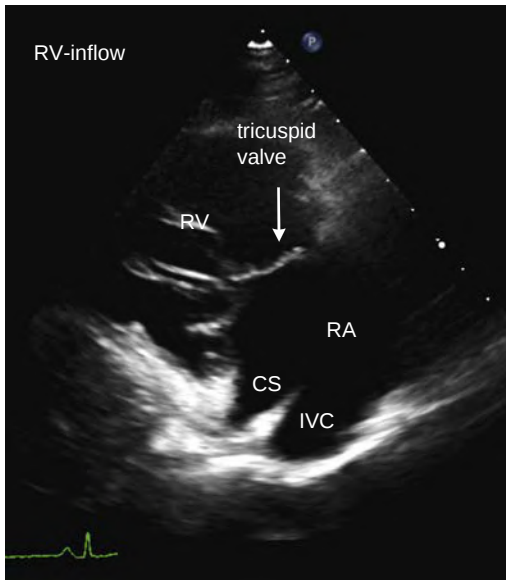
RV inflow view. From the parasternal long-axis view, the image plane is angulated medially to visualize the RV inflow view with the RV, RA, coronary sinus (CS), inferior vena cava (IVC), and tricuspid valve.
